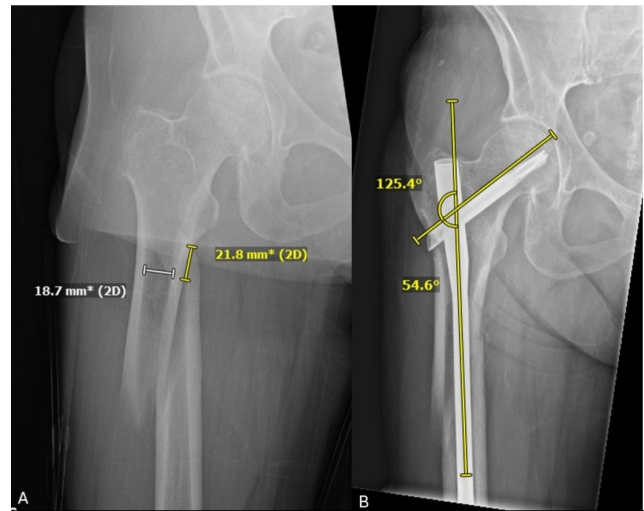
(A) Anteroposterior (AP) injury radiograph of a right proximal femur demonstrating how the canal width at the fracture site (18.7mm) and distance from the lesser trochanter (21.8mm) was measured. (B) Final follow up AP radiograph demonstrating how the final neck shaft angle was measured (125.4°). This patient was fixed with a 10mm 125° TFNA. Therefore, the canal width at the fracture site minus the diameter of the nail in this example is 8.7mm.
